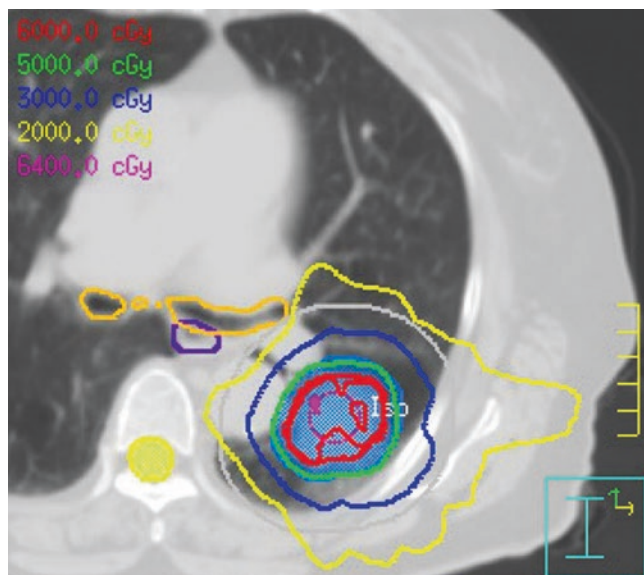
Representative axial slice from the CT images of the SBRT plan for a stage I left lower lobe cancer treated with 50 Gy in 5 fractions: PTV (blue cloud), 60 Gy isodose line (red), 50 Gy isodose line (green), 30 Gy isodose line (blue), 20 Gy isodose line (yellow), 2 cm ring expansion from the PTV for planning (gray line), esophagus (purple line), and proximal bronchial tree (orange line)
